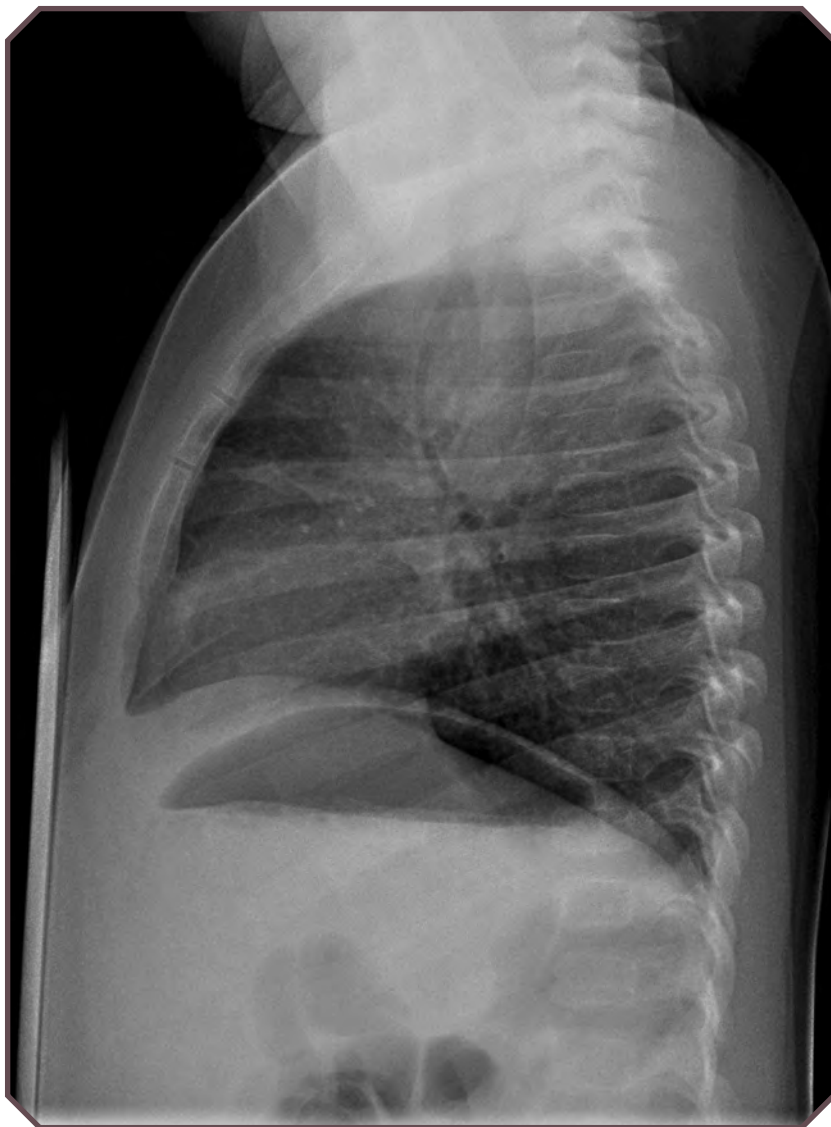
Lateral chest radiograph of a 17-month-old girl with bronchogenic cyst shows anterior bowing and narrowing of the trachea by a fluid-filled mass of the middle mediastinum centered at the level of the trachea and the aortic arch, above the carina. Image courtesy of Robert Paul Guillerman, MD, Pediatric Radiology, Texas Children's Hospital.
